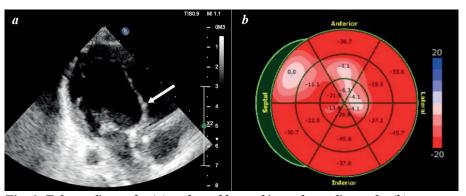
Echocardiography (a) and speckle-tracking echocardiography (b): aneurysmal bulging of the interventricular septum (indicated by an arrow), accompanied by impaired longitudinal strain in the basal septal segment.
